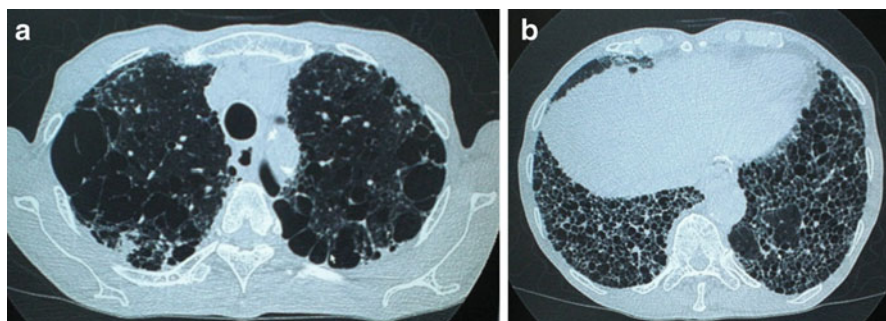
High-resolution computed tomography (HRCT) of a male smoker aged 77 years with combined pulmonary fibrosis and emphysema. (a) Presence of paraseptal emphysema and subpleural bullae in bilateral upper lobes. (b) Images of subpleural honeycombing and traction bronchiectasis in bilateral lower lobes
